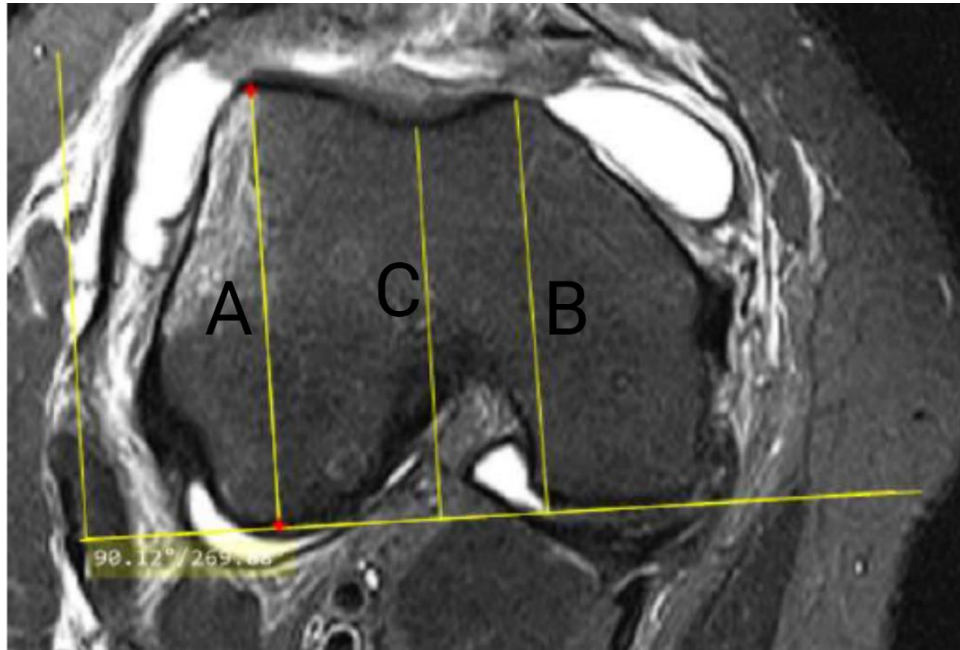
Axial MRI of the knee.
